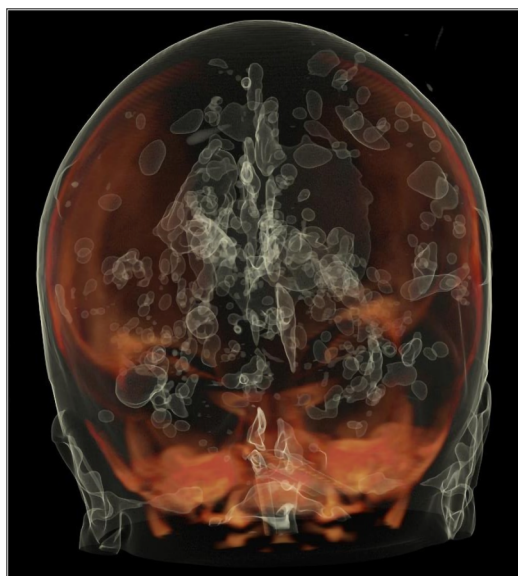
Three-dimensional images reconstructed using the coronal view of the CT scan. Abbreviation: CT, computed tomography.
